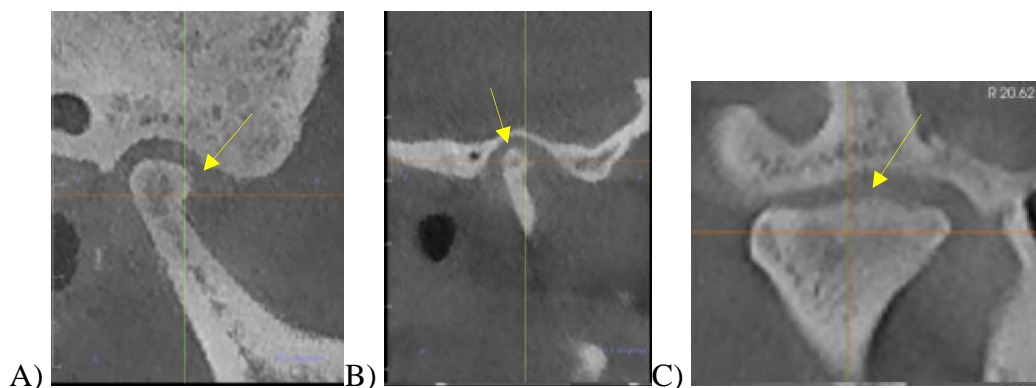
CBCT cross-sections depicting osteoarthritic changes of the TMJ A) Sagittal view showing osteophyte formation at the anterior aspect of the right condyle B) Sagittal view demonstrating subchondral cyst formation along the anterior surface of right condyle C) Coronal view depicting cortical erosion at the superior aspect of the right condyle
